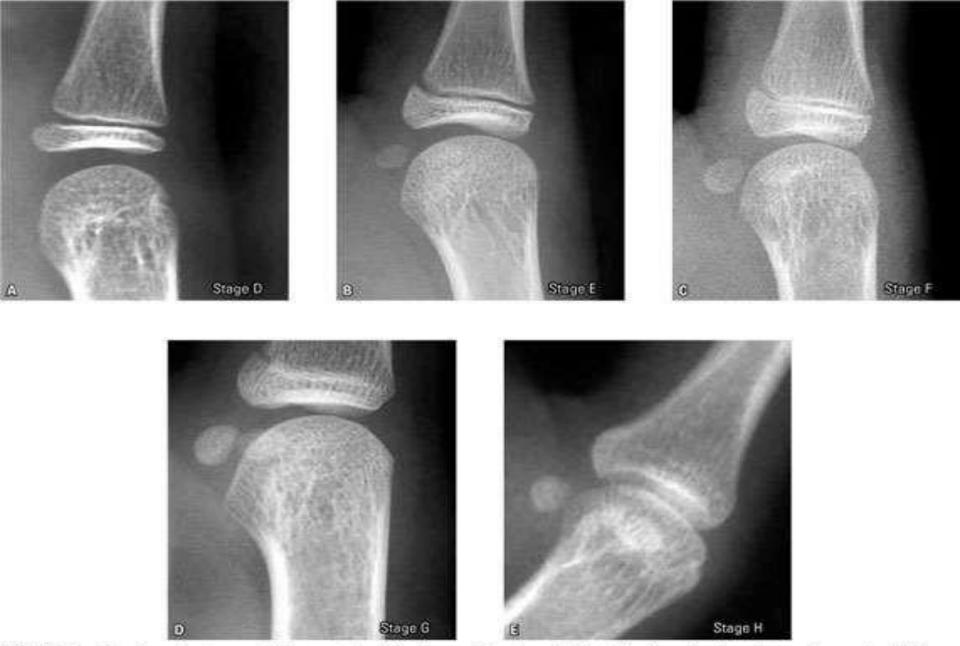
Epiphyseal stages of the proximal phalanx of the thumb identified on hand-wrist radiograph: A) Precapping (Stage D); B) Capping (Stage E); C) Fusion onset (Stage F); D) Fusion in progress (Stage G); E) fusion complete (Stage H).
